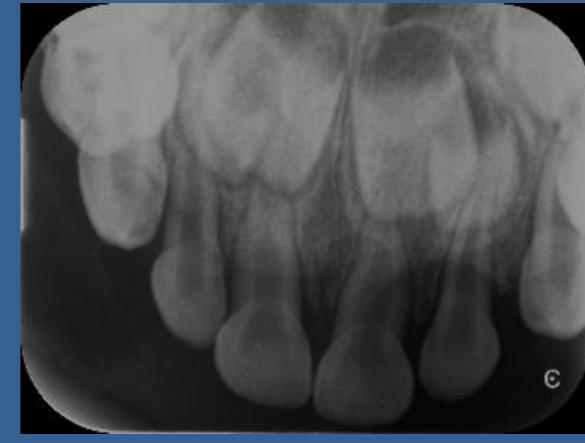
No periapical abscesses or signs of pulp alteration are evident.
